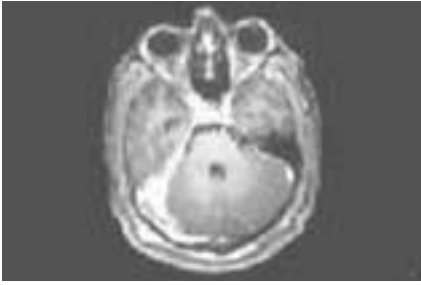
Magnetic resonance imaging of the patient showing right disseminated sinus thrombosis, axial section.
